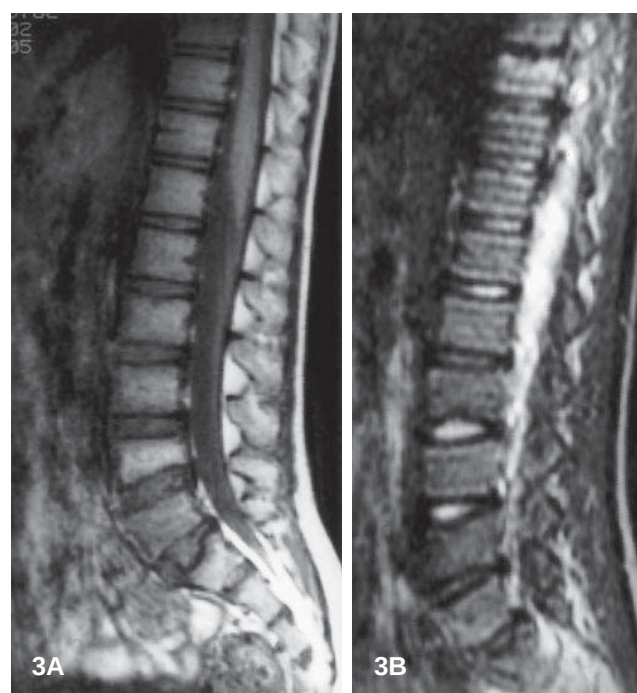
Case 1. A Sagittal T1-weighted spin echo (SE) and B T2-weighted SE MR images of the lower thoracic and lumbar spine. L5 shows increased signal intensity (SI) on the T1-weighted sequence and isointensity on the T2-weighted sequence, indicating fatty replacement consistent with a healed lesion. T10 shows decreased SI on the T1-weighted sequence and increased SI on the T2-weighted sequence, indicating oedema consistent with an active process (note that the patient has six lumbar vertebrae). Collapse of the superior endplate of the sacrum is also identified, indicating previous involvement
